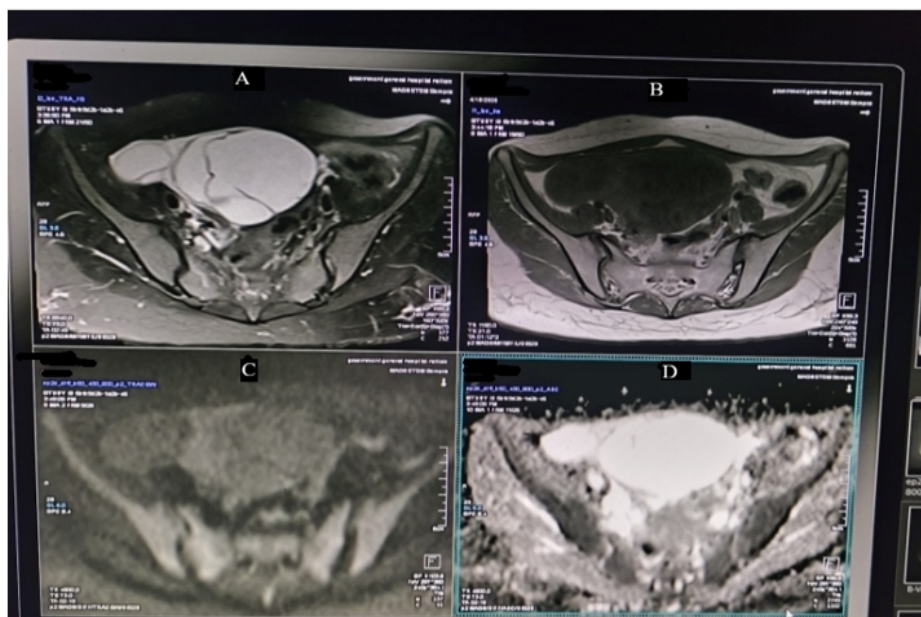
A. Axial T2 weighted image of MRI pelvis showing well defined multiloculated hyperintense lesion in right adnexa with thin internal septations. B. Axial T1 weighted image the lesion is hypointense. C. DWI image at b1000 showing no Restricted diffusion. D. ADC image showing facilitated diffusion
